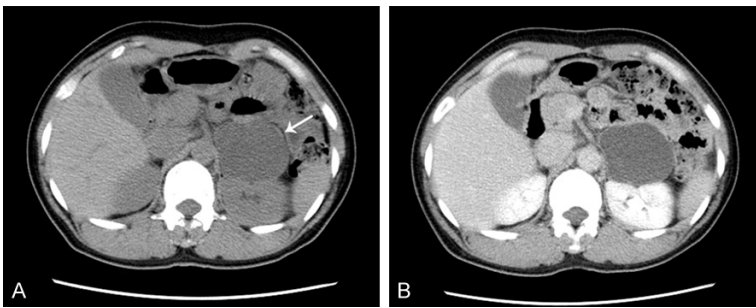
CT images of cystic adrenal ganglioneuroma. The images reveal a homogeneous and low-density left adrenal cystic mass (arrow, 63 × 56 × 60 mm) with no contrast enhancement, no septation, no solid component or calcification. (A. CT scan; B. contrast-enhanced CT scan).
